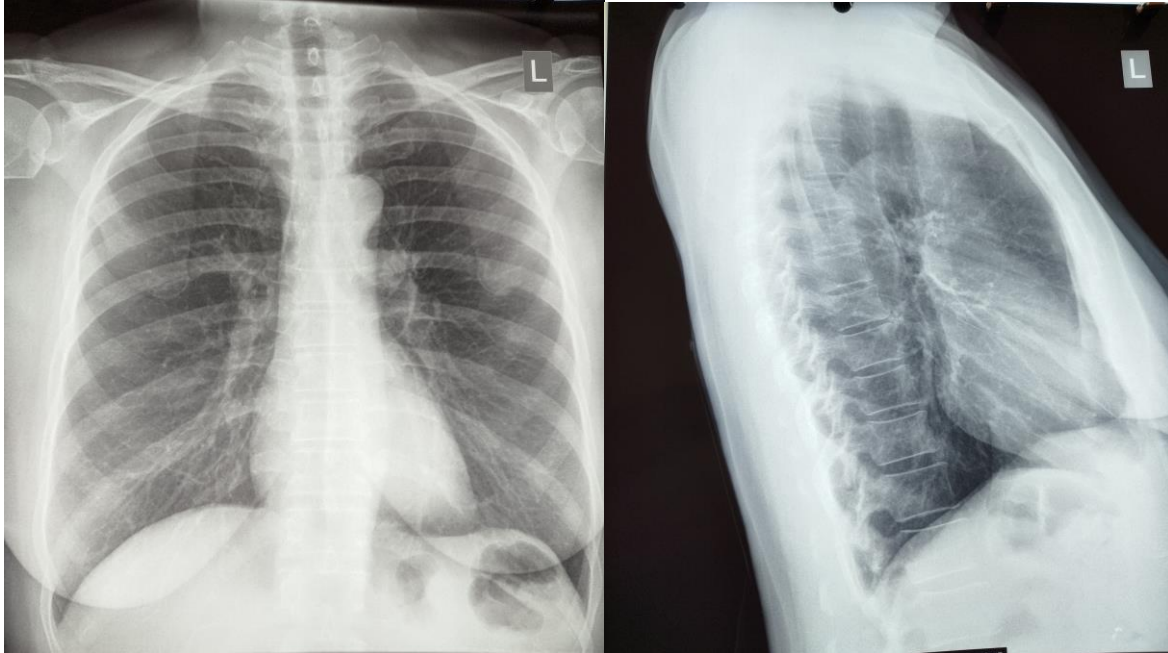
Posterior-anterior radiograph of 60- year-old women patient with initial consolidation
